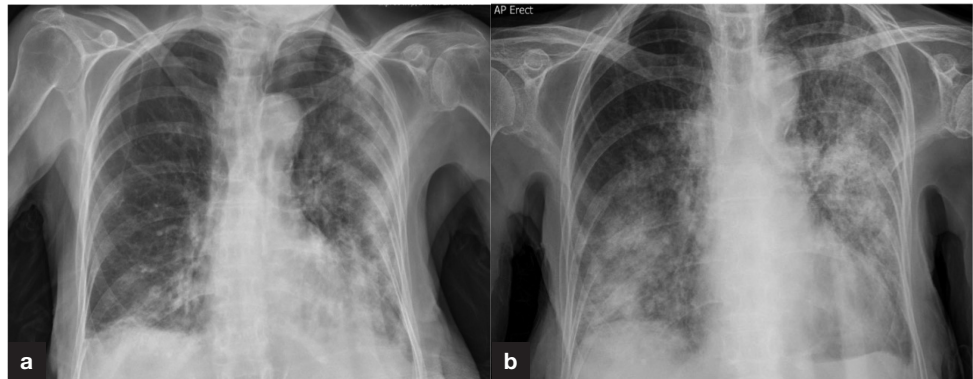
Chest X-ray (a) on day 0 confirmed COVID-19 infection and (b) day 6 (post thrombolysis).
